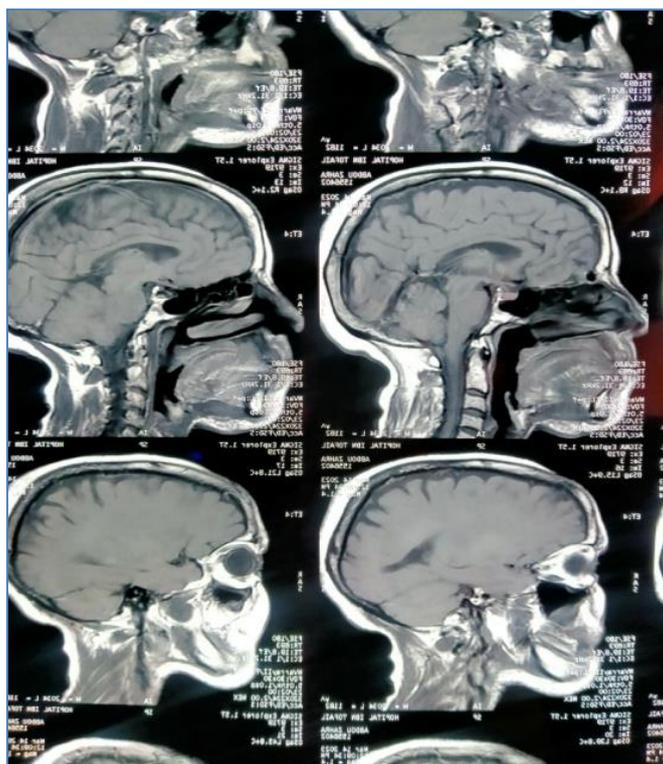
MRI sagittal section showing a nodular formation of the mobile tongue lateralized to the left
